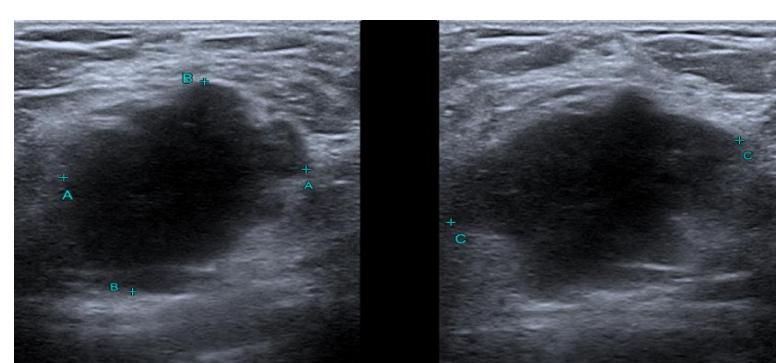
Ultrasound showing breast lesion
